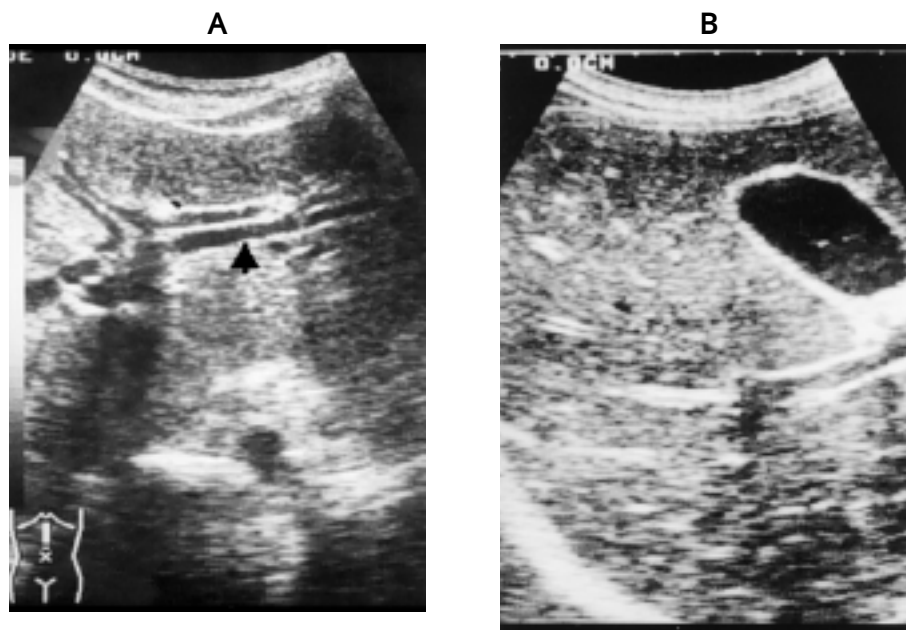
Ultrasonographic hepatobiliary findings in case of *Opisthorchis* infection: 2-A and 2-B showed dilatation of intrahepatic bile duct (arrow) and intrahepatic enhanced echoes, respectively.
